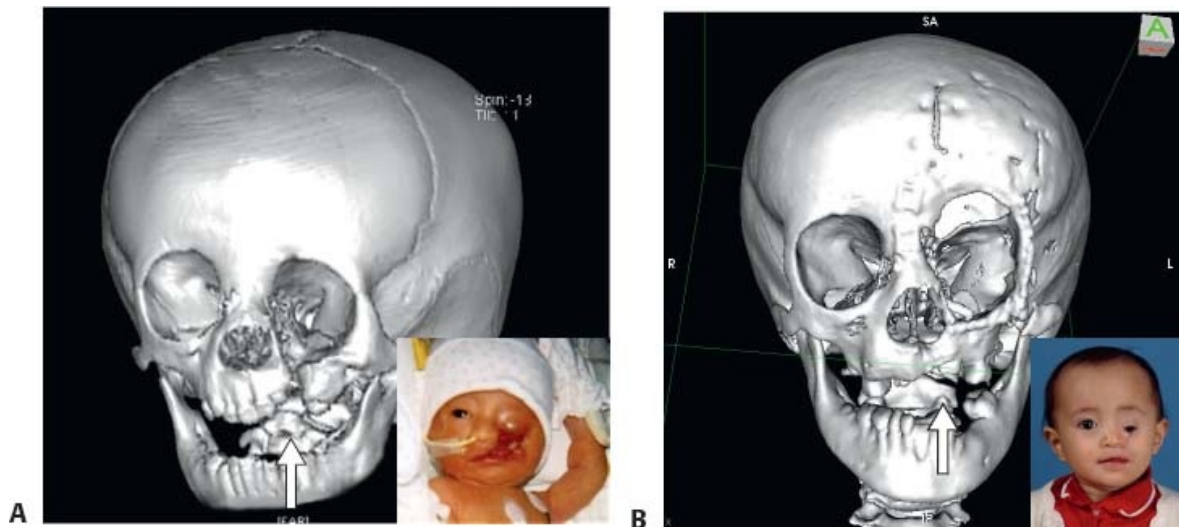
• 3D CT scan of Tessier no. 4 orbitofacial cleft and accompanying inset of patient with no. 4 cleft. A. CT scan at birth demonstrates the osseous defect with communication between the orbit, maxillary sinus, and oral cavity. B. CT scan demonstrates bone healing of the maxilla and alveolus after primary soft tissue and BMP-2 repair. Orbital reconstruction is planned in the future.
